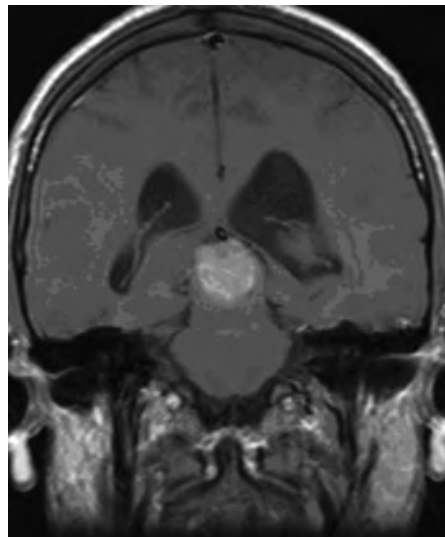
MRI shows cerebral mass with hydrocephalus
